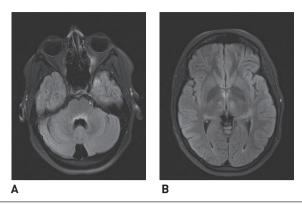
Transversal MRI FLAIR images presenting typical NMO dorsal brainstem (A) and midbrain (B) lesions of one of our NMO patients with AQP4-IqG seropositivity.
